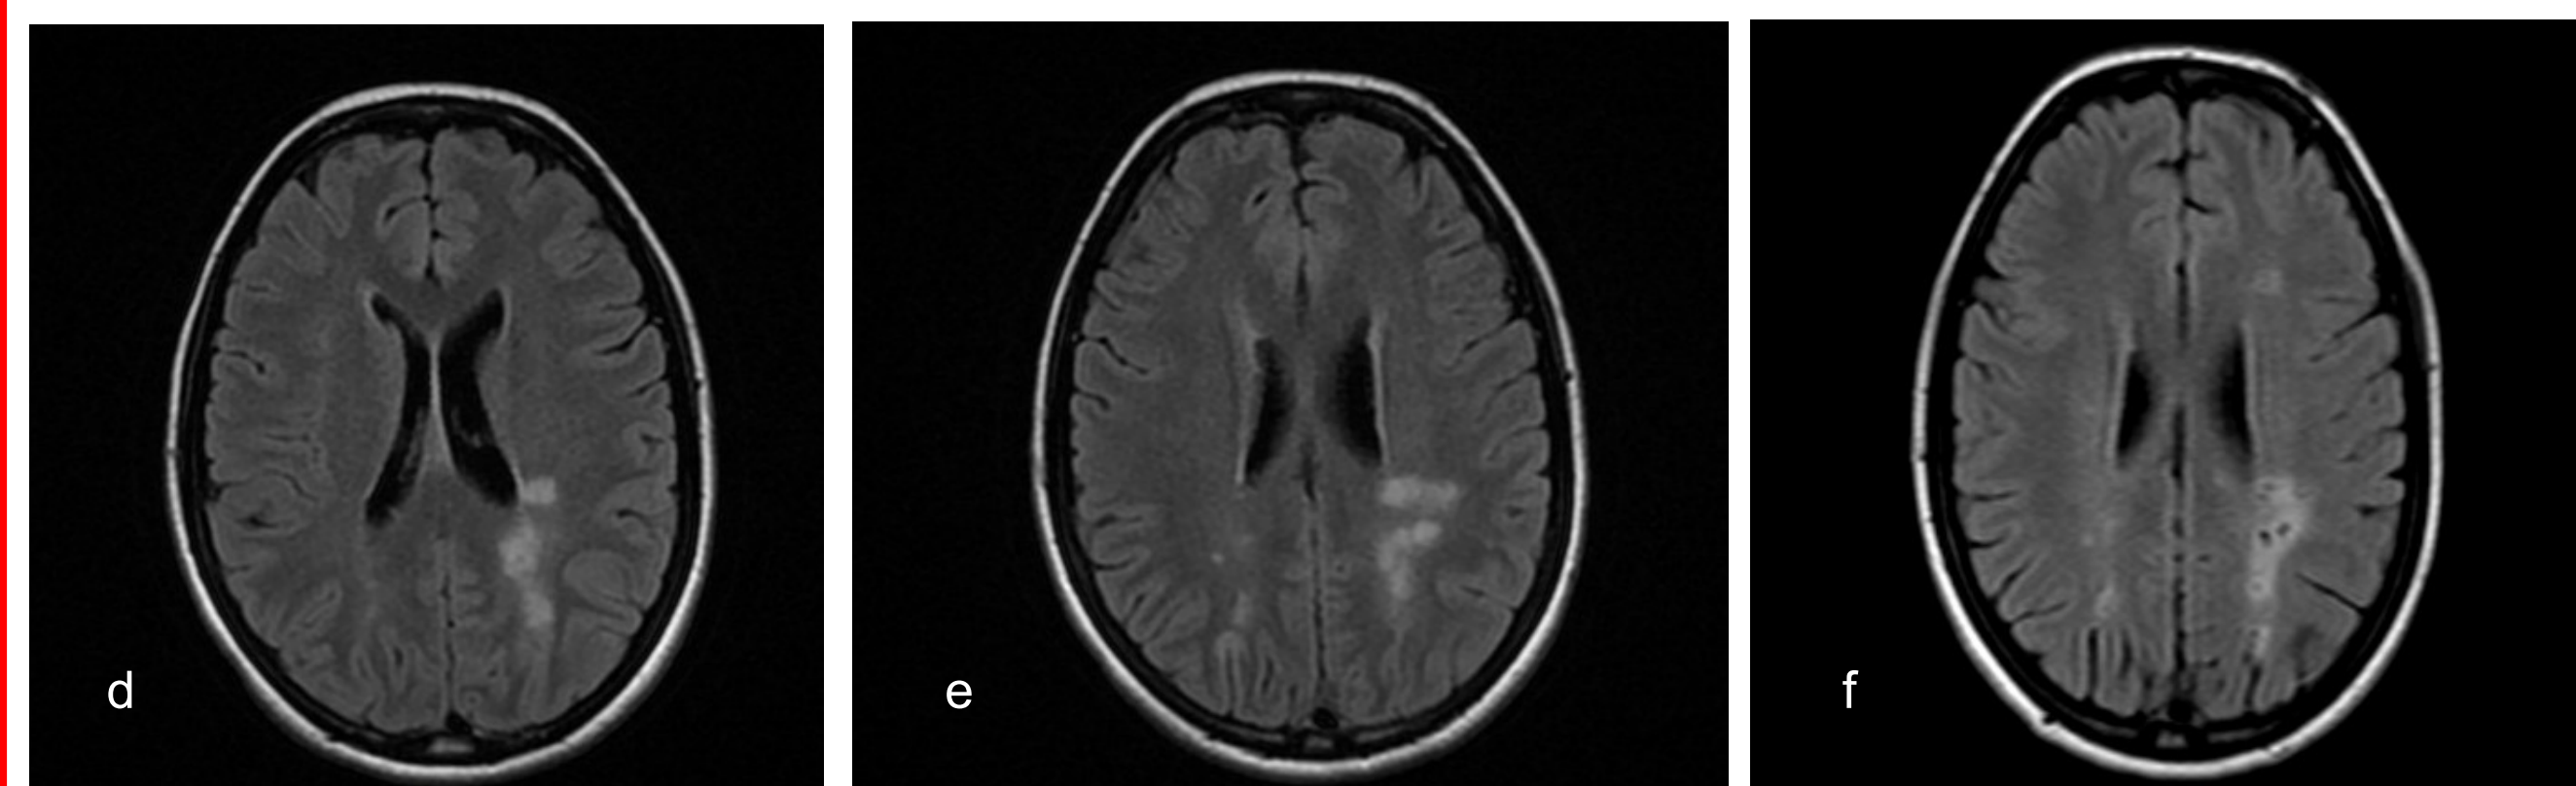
d,e,f: follow-up MRI after 20 days (d,e) and 1 year (f) with focal gliosis
